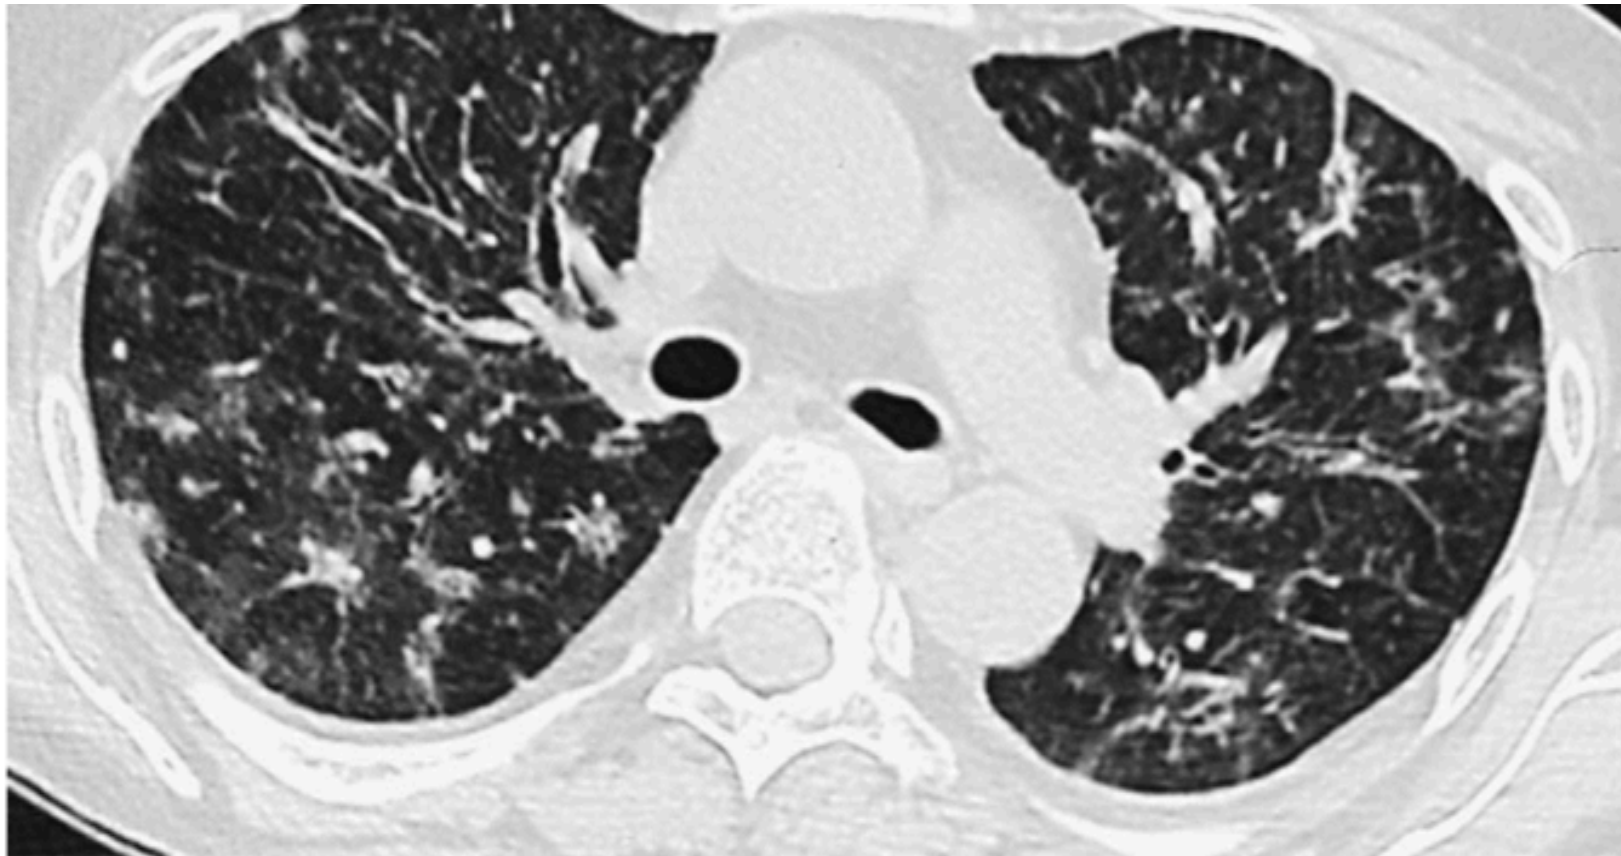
HRCT appearance in a 42-year-old female patient with acute lymphoblastic leukemia, showing diffuse GGO with inhomogeneous distribution unrelated to secondary lobules and centrilobular nodules.
